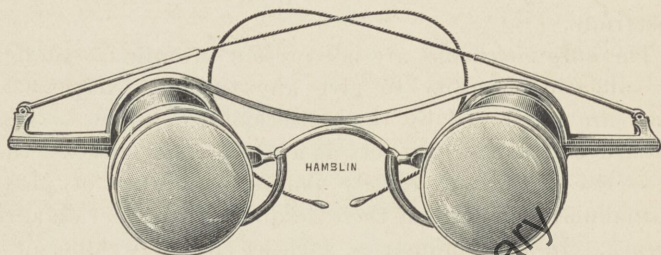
GALILEAN SPECTACLES.
